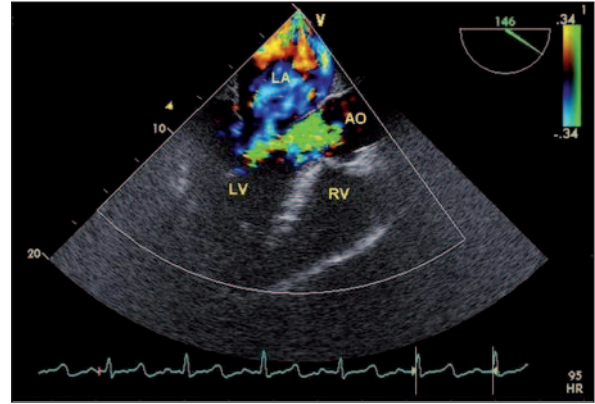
Color Doppler echocardiography demonstrates severe aortic regurgitation in aortic long-axis view of transesophageal echocardiography.
